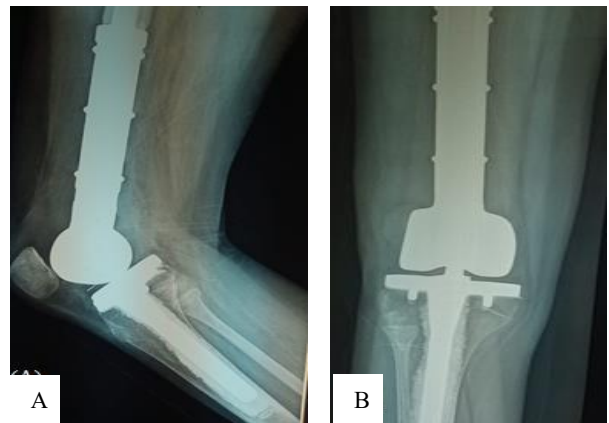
(A and B): Post-op X-rays (A) lateral view and (B) AP view.
